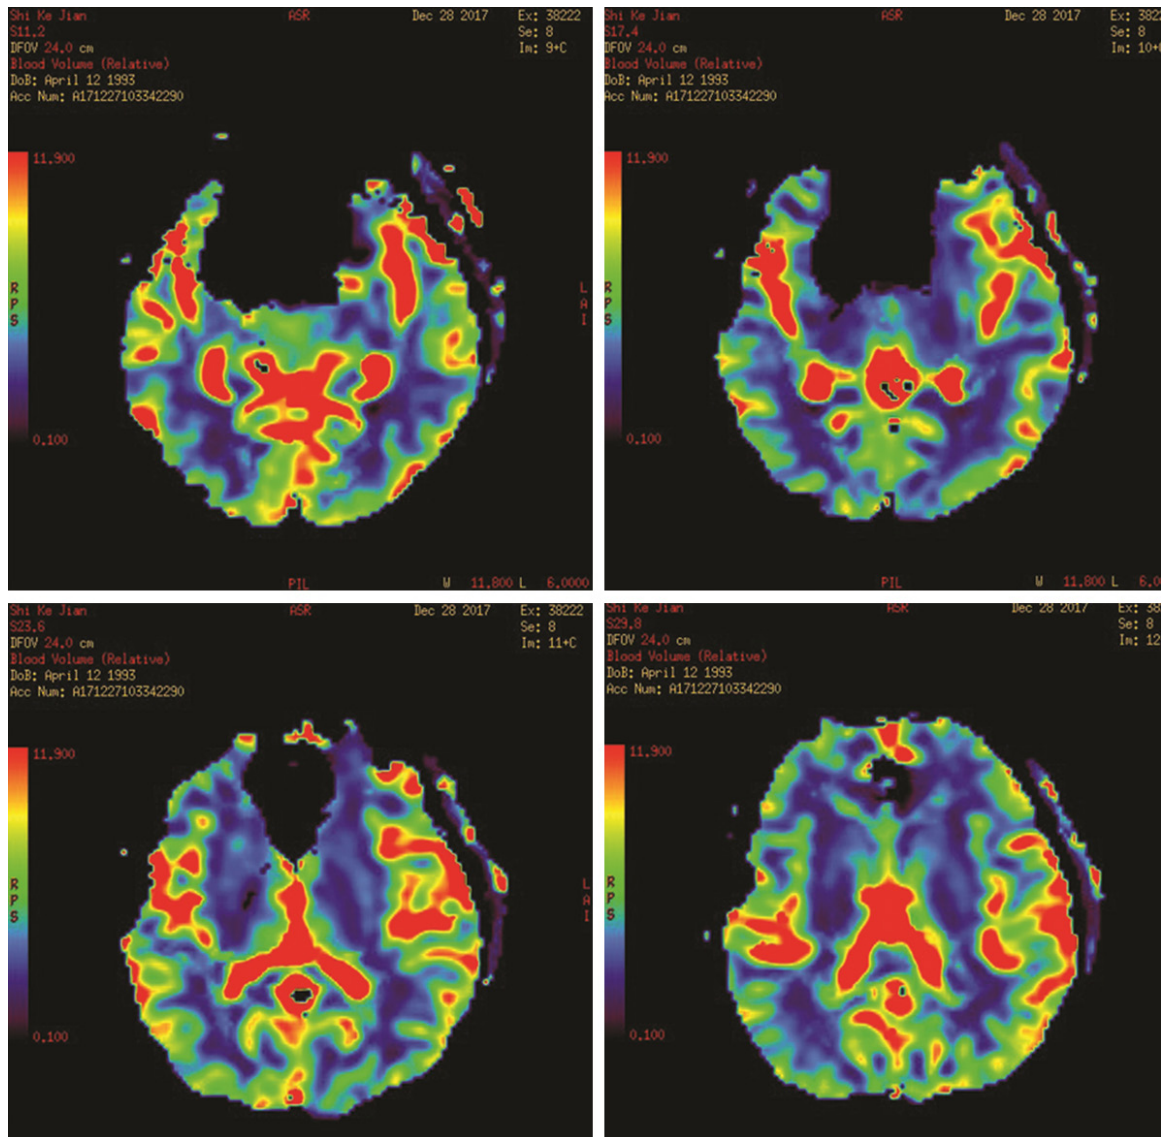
Postoperative perfusion-magnetic resonance imaging. No abnormalities or recurrent MCA-AN were detected.
